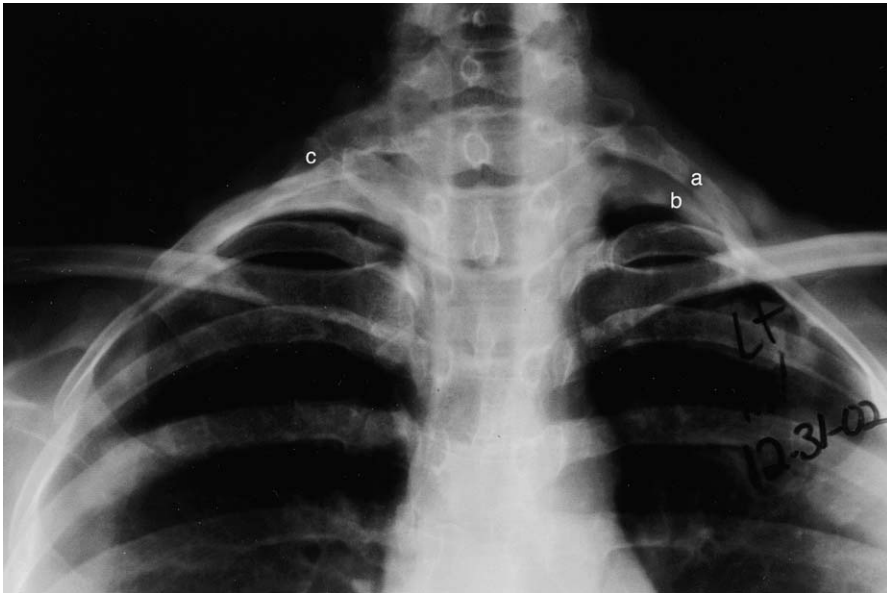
This female radiology technician had a transaxillary resection of the left first rib leaving the cervical rib intact. Radiograph of the cervical spine shows the bilateral cervical ribs (the left one) (a) is 1.75-inch long with severe symptoms, and the absent (surgically removed) left first rib (b). The patient had very short-lasting and minimal improvement with full-blown recurrent symptoms on the left side. The right cervical rib is approximately 0.75-inch long (c) with minimal symptoms. (From The Christine M. Kleinert Institute for Hand and Microsurgery, Inc.; with permission.)
